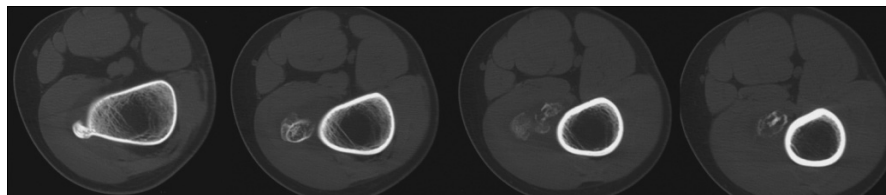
Axial three-dimensional computed tomography showed continuity of the marrow space into the lesion, no irregular calcification and no evidence of a fracture line
